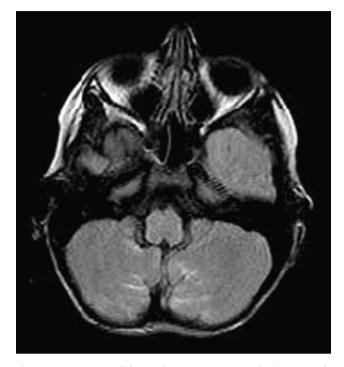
T2 FLAIR axial MRI demonstrates patchy increased signal intensity in the cerebellar hemispheres bilaterally. Diffusion imaging was normal as was the supratentorial brain.
